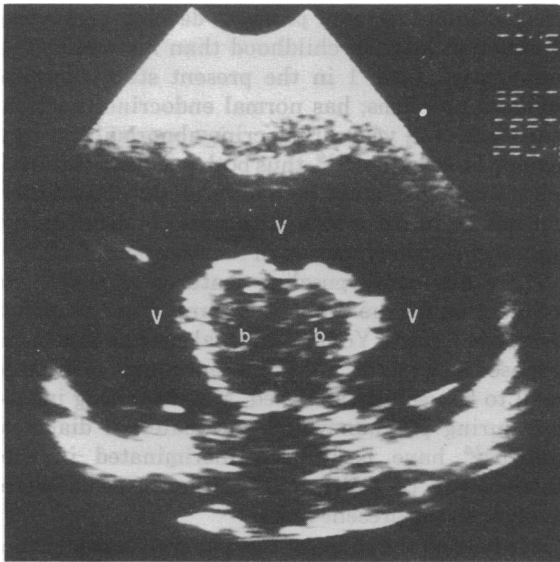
Coronal ultrasound scan in Case 6 showing a dilated single ventricle (v) at the level of the basal ganglia (b), consistent with holoprosencephaly
